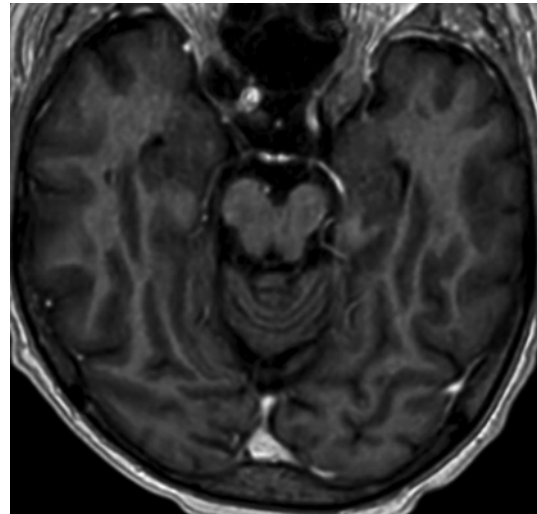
Normal post-contrast T1 MRI sequences.
